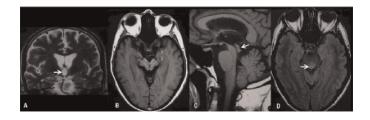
Abbreviations: ADC: apparent diffusion coefficient; CBS: corticobasal syndrome; FLAIR: fluid-attenuated inversion recovery; MSA: multiple system atrophy; MSA-C: multiple system atrophy with predominant cerebellar dysfunction; MSA-P: multiple system atrophy with predominant parkinsonian features; PD: Parkinson's disease; PSP: Progressive supranuclear palsy; SCP: superior cerebellar peduncle.
